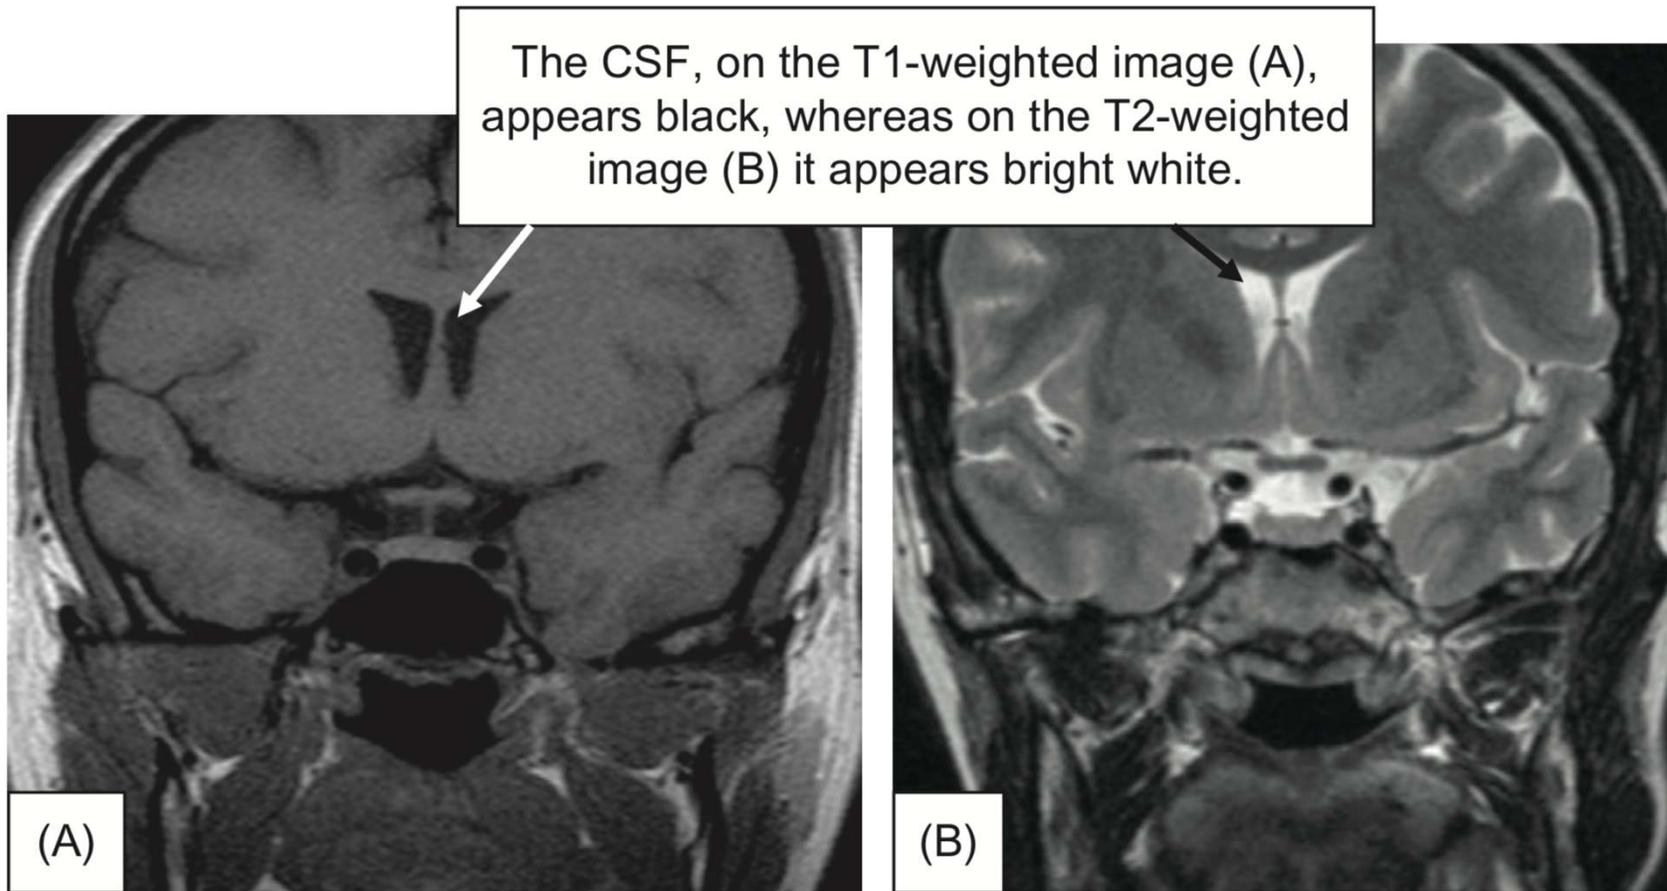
(A) Coronal T1-weighted image without contrast, and (B) coronal T2-weighted image.
